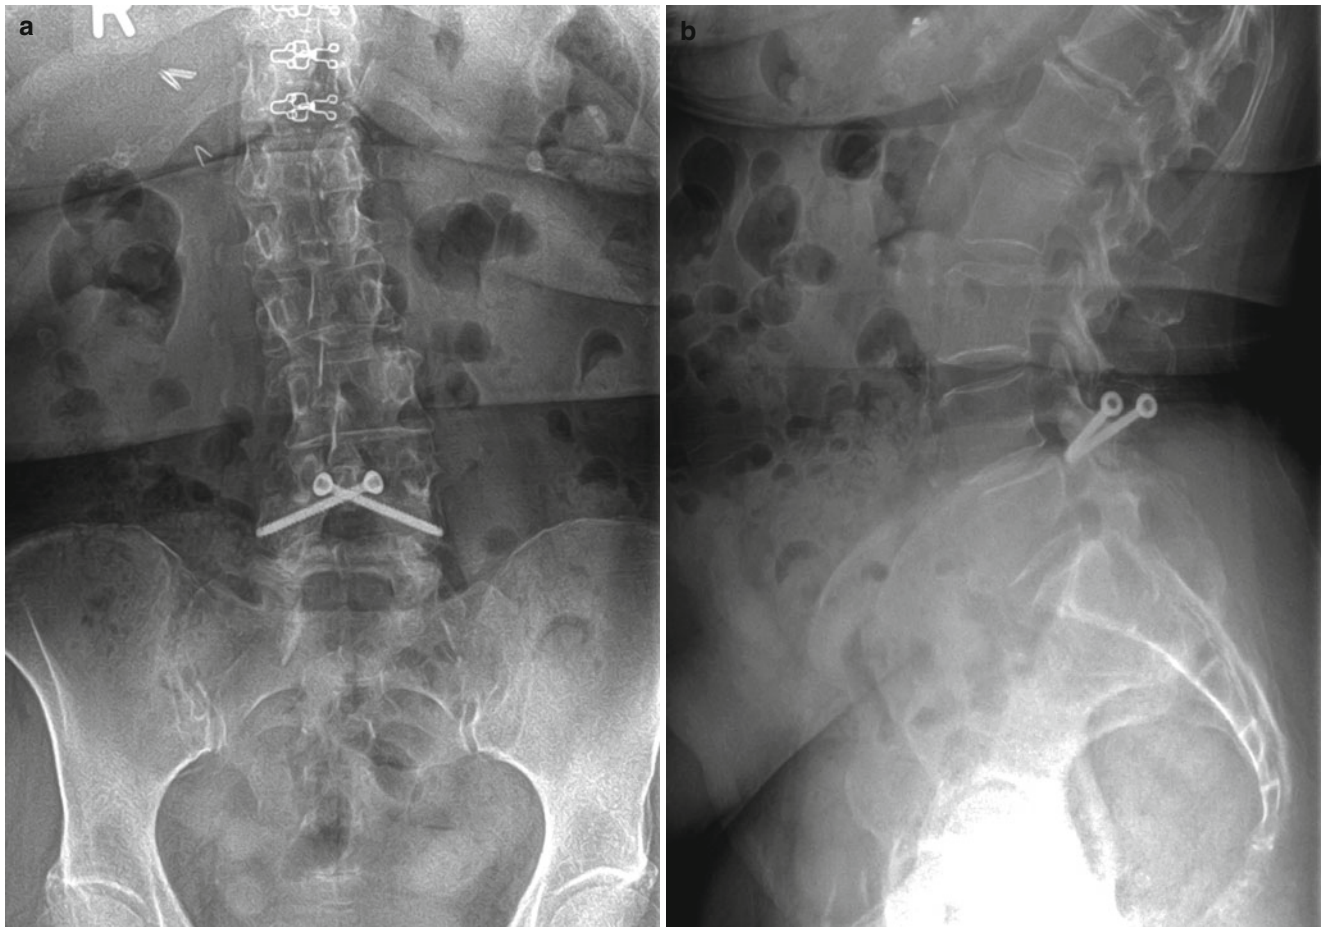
Anteroposterior (a) and lateral (b) radiographs showing the proper placement of translaminar facet screws
